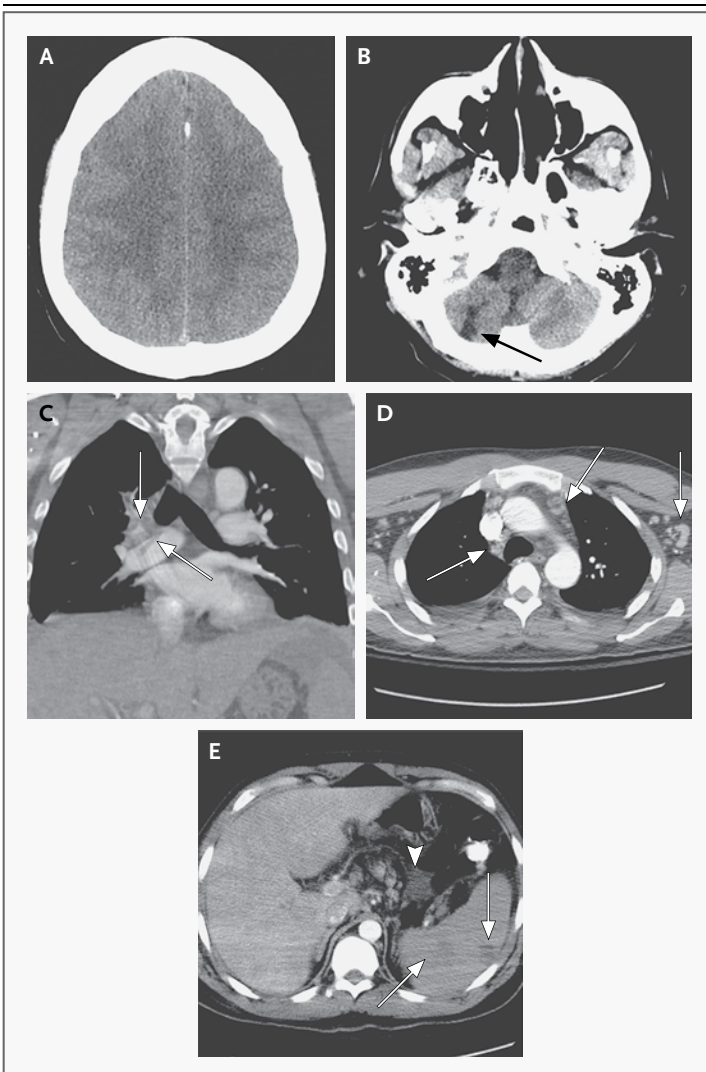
CT Imaging Studies.
